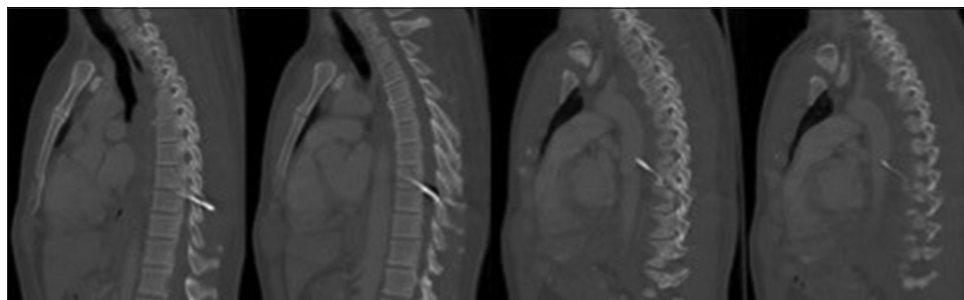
Sagittal computed tomography with contrast of the thorax demonstrating an 8 cm linear foreign body extending through the spinal canal and terminating in the lumen of the descending thoracic aorta
